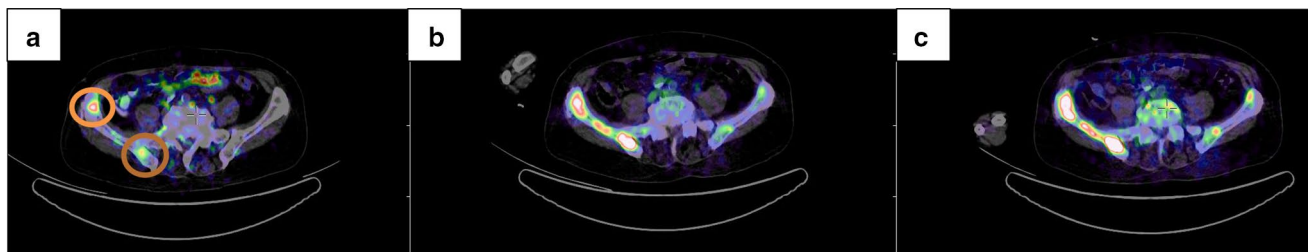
Uptake in two metastatic lesions on a. $[^{68}\text{Ga}]\text{Ga-PSMA-617}$, b. $[^{68}\text{Ga}]\text{Ga-DOTA}^{\text{ZOL}}$ at 45 min p.i. and c. $[^{68}\text{Ga}]\text{Ga-DOTA}^{\text{ZOL}}$ at 2.5 h p.i., showing higher and progressive uptake with $[^{68}\text{Ga}]\text{Ga-DOTA}^{\text{ZOL}}$ as a result of enhanced lesion to normal bone uptake
